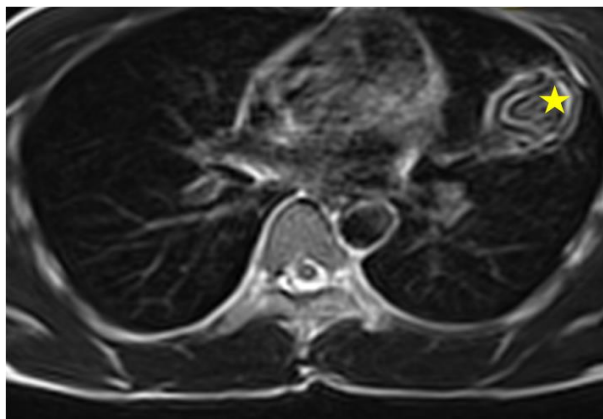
MRI image (star) show the cyst capsule which is hypointense on T2 weighted image (hypointense rim sign). The folded membranes within cysts are T2 hypointense.
